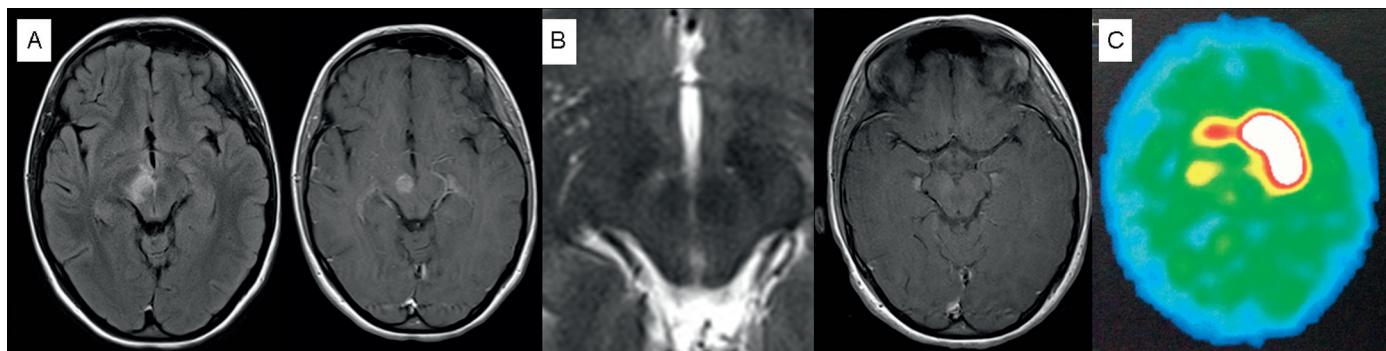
MRI Findings. (A) Baseline: left, transversal FLAIR image; right, transverse T1-weighted image. A $1.1 \times 0.9 \times 1.0$ -cm gadolinium-enhancing lesion in the right upper cerebral peduncle with perifocal edema is shown. (B) Follow-up MRI after 4 months: left, only a slightly smaller right red nucleus compared to the left, and a small hyperintensity in the area of the right substantia nigra indicating discrete residual changes on T2-weighted imaging; right, complete remission on contrast-enhanced T1-weighted MRI. (C) DaT-SPECT 5 months after symptom onset shows nearly absent DaT binding in the right striatum. Abbreviations: DaT-SPECT, Dopamine Transporter Single-photon Emission Computed Tomography; FLAIR, Fluid-attenuated Inversion Recovery; MRI, Magnetic Resonance Imaging.
